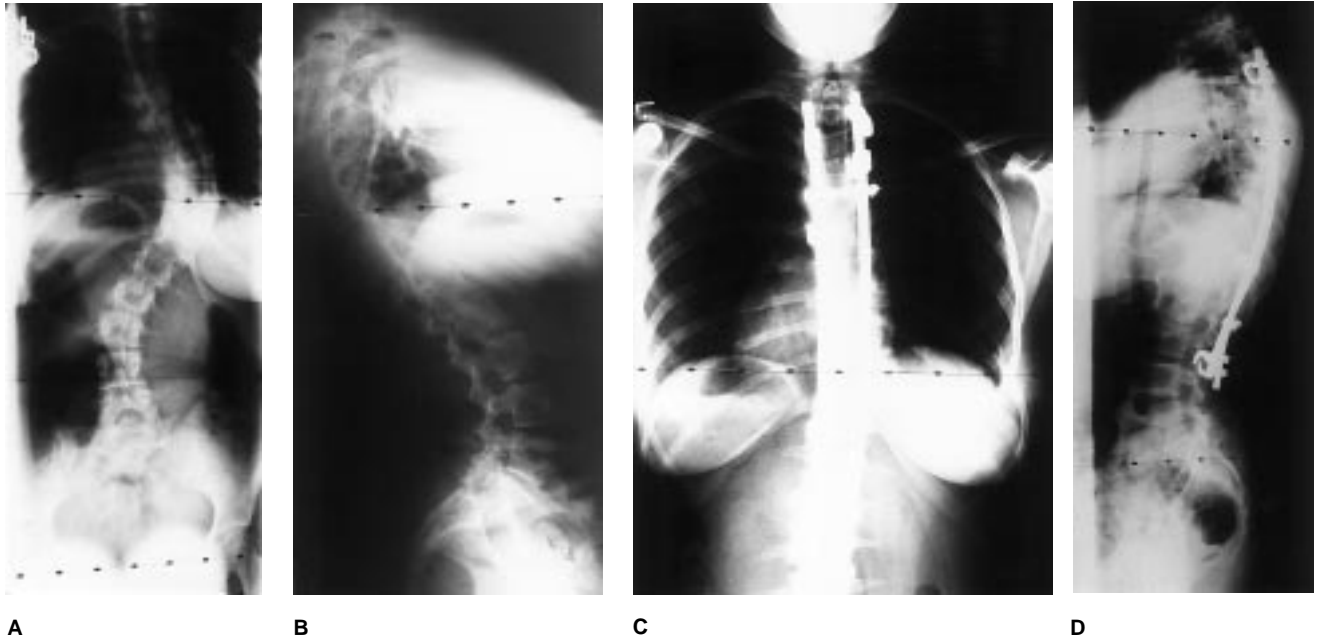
A and B, Preoperative radiographs of a girl aged 13 years 10 months with a 68-degree right thoracic curve and a 38-degree left lumbar curve. C and D, Postoperative views of same patient at age 14 years 5 months, after posterior spinal fusion performed with CD instrumentation following first-stage anterior spinal release/fusion performed because of the rigid nature of the thoracic curve. Right thoracic curve measures 20 degrees; left lumbar curve, 18 degrees.
